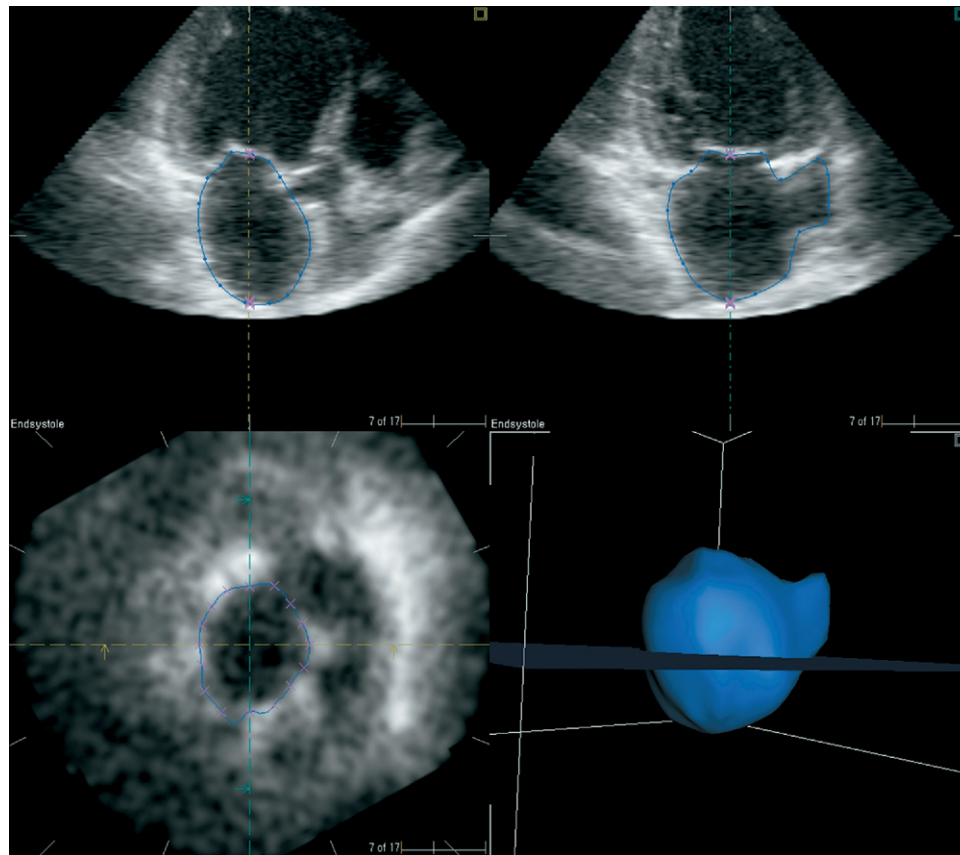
Representative example of left atrial (LA) volume measurement using real-time 3-dimensional echocardiography. Volume was measured at ventricular end systole just before opening of mitral valve by tracing LA areas in 8 radial planes 22.5 degrees apart from one another. Color figure online.
